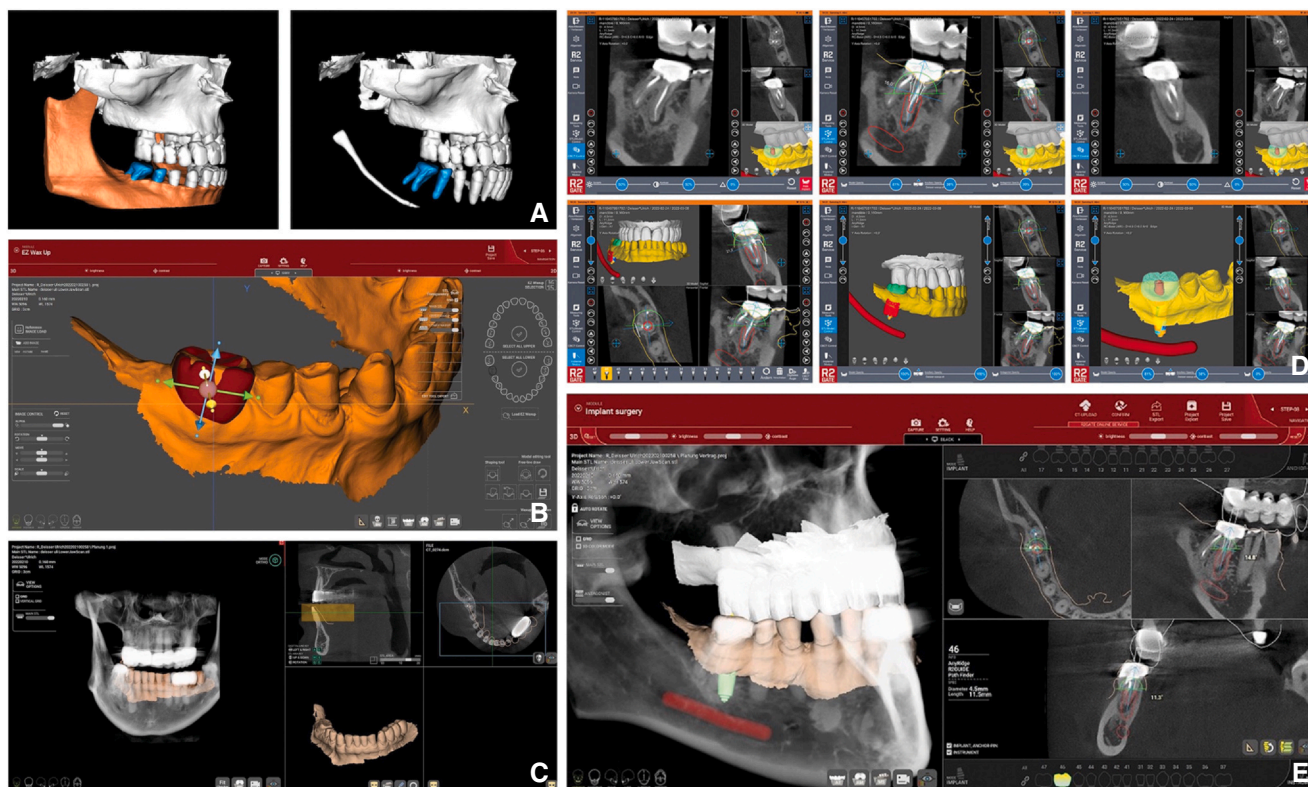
Preoperative implant planning with artificial intelligence. A, Data segmentation. B, Tooth design. C, Digital scan and radiographic dataset alignment. D, Implant planning and selection. E, Complete dataset.
